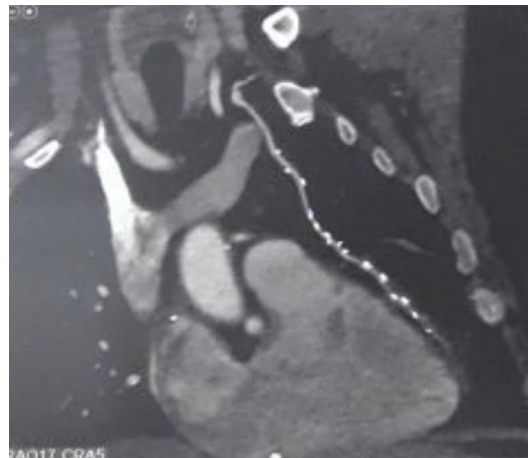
Representative image of CT coronary angiography showing left internal mammary artery (LIMA) patch with patent LIMA-left anterior descending artery anastomosis
